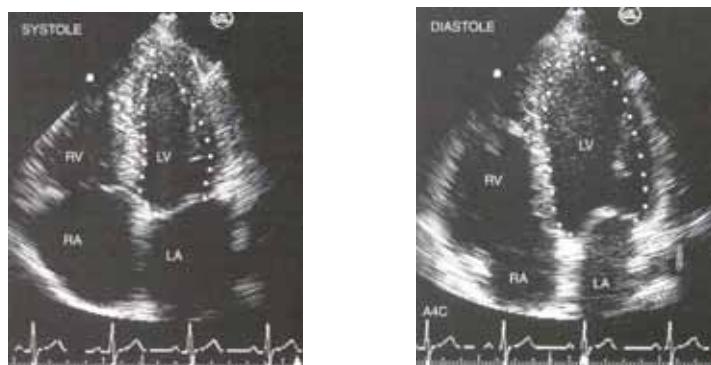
Transthoracic Echocardiography can be used to determine Preload and Stroke Volume/Cardiac Output. Preload can be evaluated in two ways: By estimating the left ventricle end diastolic volume and by evaluating the inferior vena cava diameter. Stroke volume/cardiac output can also be evaluated in two ways: By using the Simpson Method and by measure how much blood flows through the left ventricle outflow tract during each heart beat.
